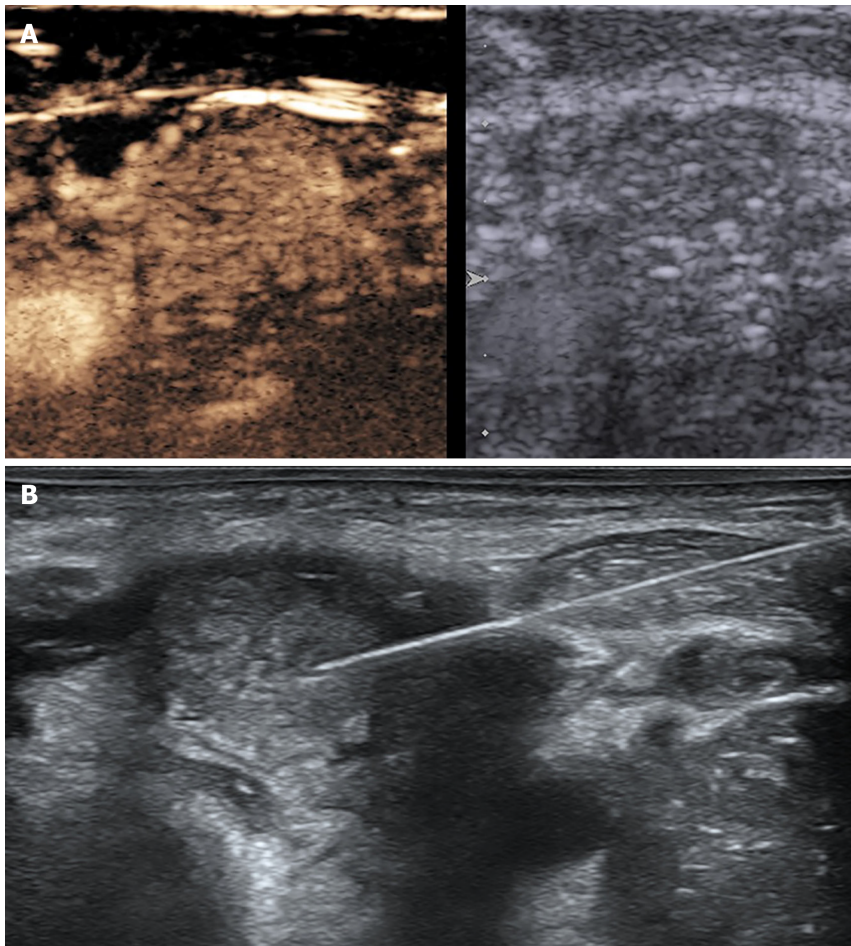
Ultrasound images of lymph node and thyroid. A: Contrast-enhanced ultrasound of the left cervical lymph node; B: Fine-needle aspiration cytology of the left lobe of the thyroid.
